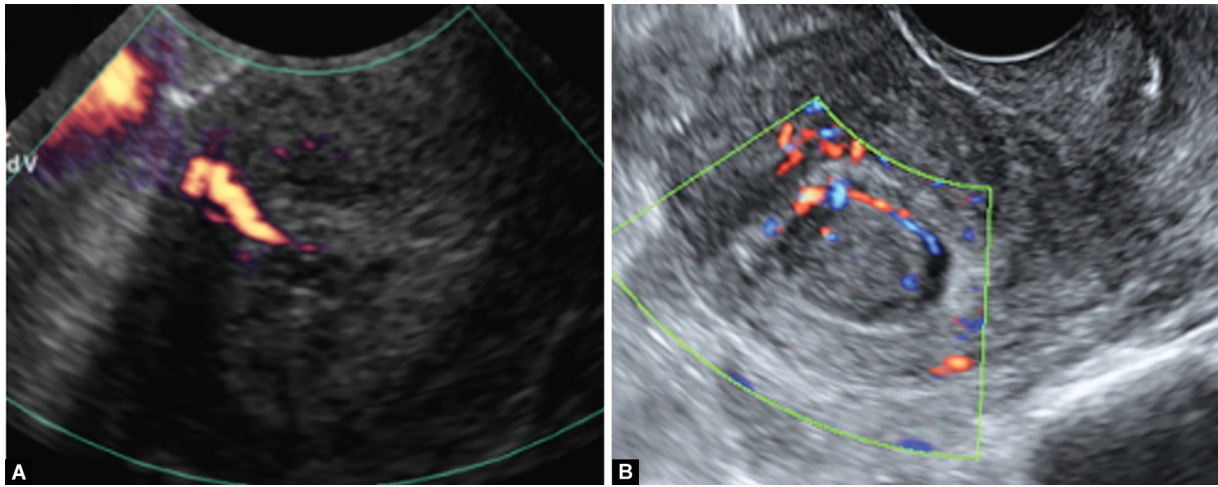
to D: (A) 2D/3D ultrasonography; (B) Hugh submucosal leiomyoma; (C) Nonhomogeneous echogenic; (D) 3D mapping of color vessels
